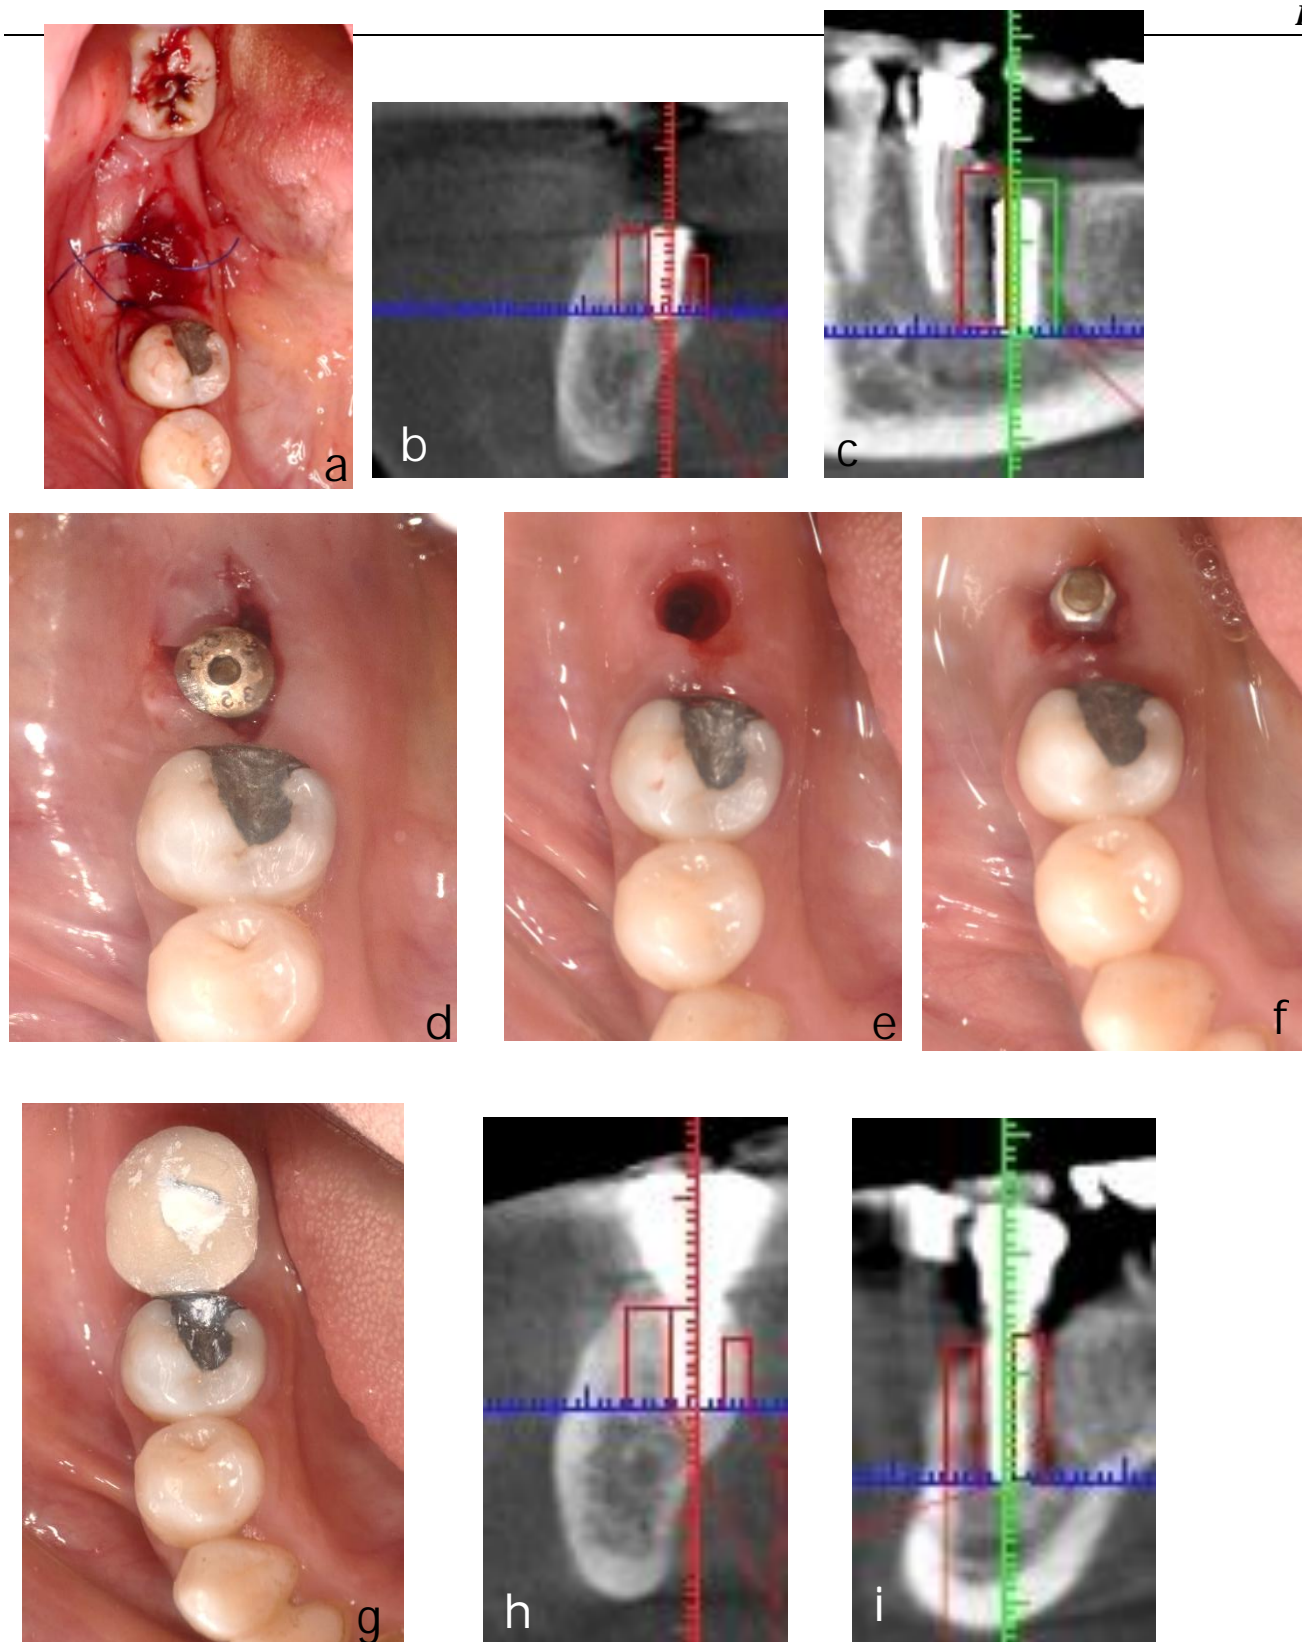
(a) Showing clinical view of gingival former replacing tooth no. 36 after six months . (b) Showing clinical view of soft tissue around implant after gingival former removal replacing tooth no. 36 (c) Showing smart peg application and implant stability measurements of implant replacing tooth no. 36 (d) Showing final crown cementation over implant replacing tooth no. 36 (e) Showing radiographic assessment of crestal bone level of buccolingual postoperative cross section view of crown was cemented over implant replacing tooth no. 36 (f) Showing radiographic assessment of crestal bone level of mesiodistal postoperative cross section view of crown was cemented over implant replacing tooth no. 36
